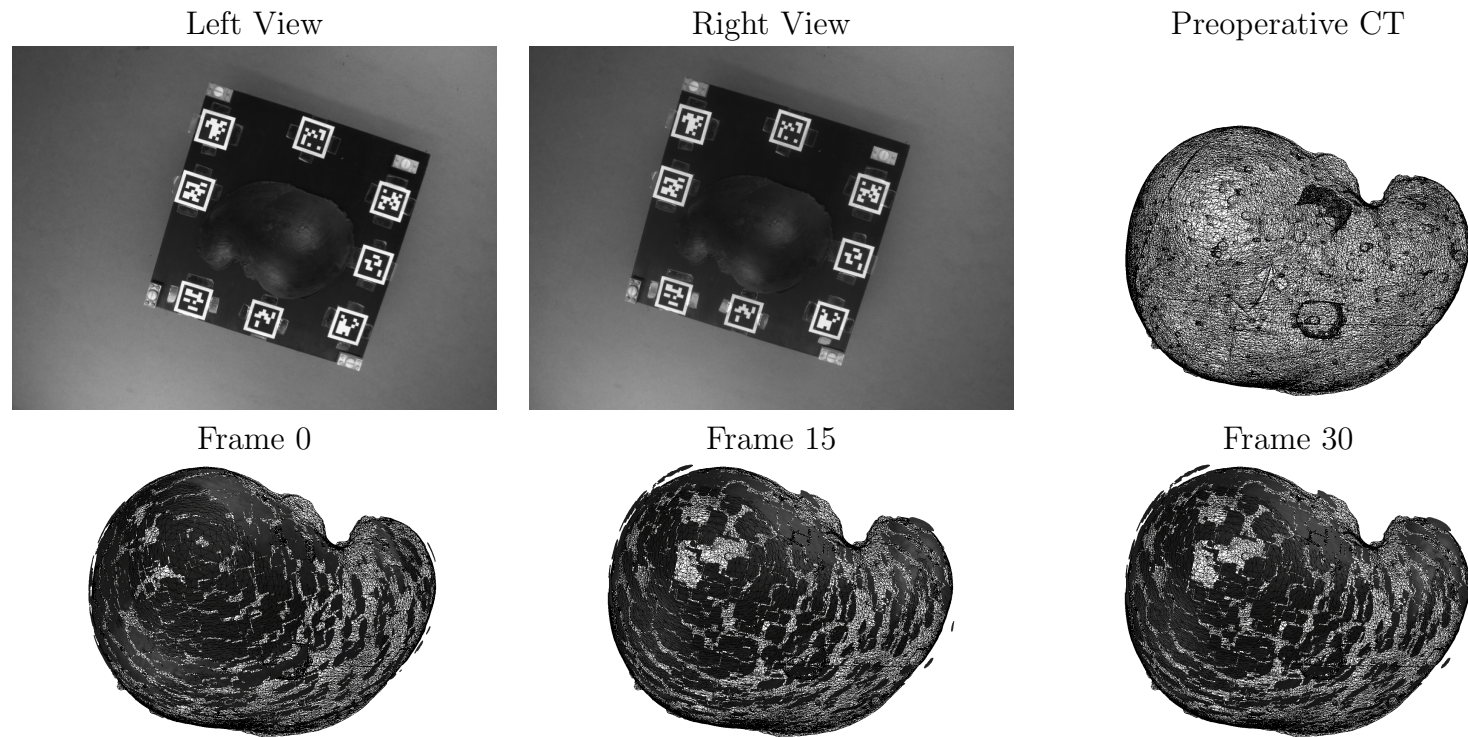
Qualitative Surface Registration Error (SRE) Results - Translation+Rotation. The left and right (non-rectified) views from the stereo camera are shown at the initial frame (frame 0). The preoperative *CT* scan is shown in a top-down view. The recovered stereo reconstructions (shown in darkest grey), registered to the preoperative *CT* scan, are shown at frames 0, 15, and 30.
